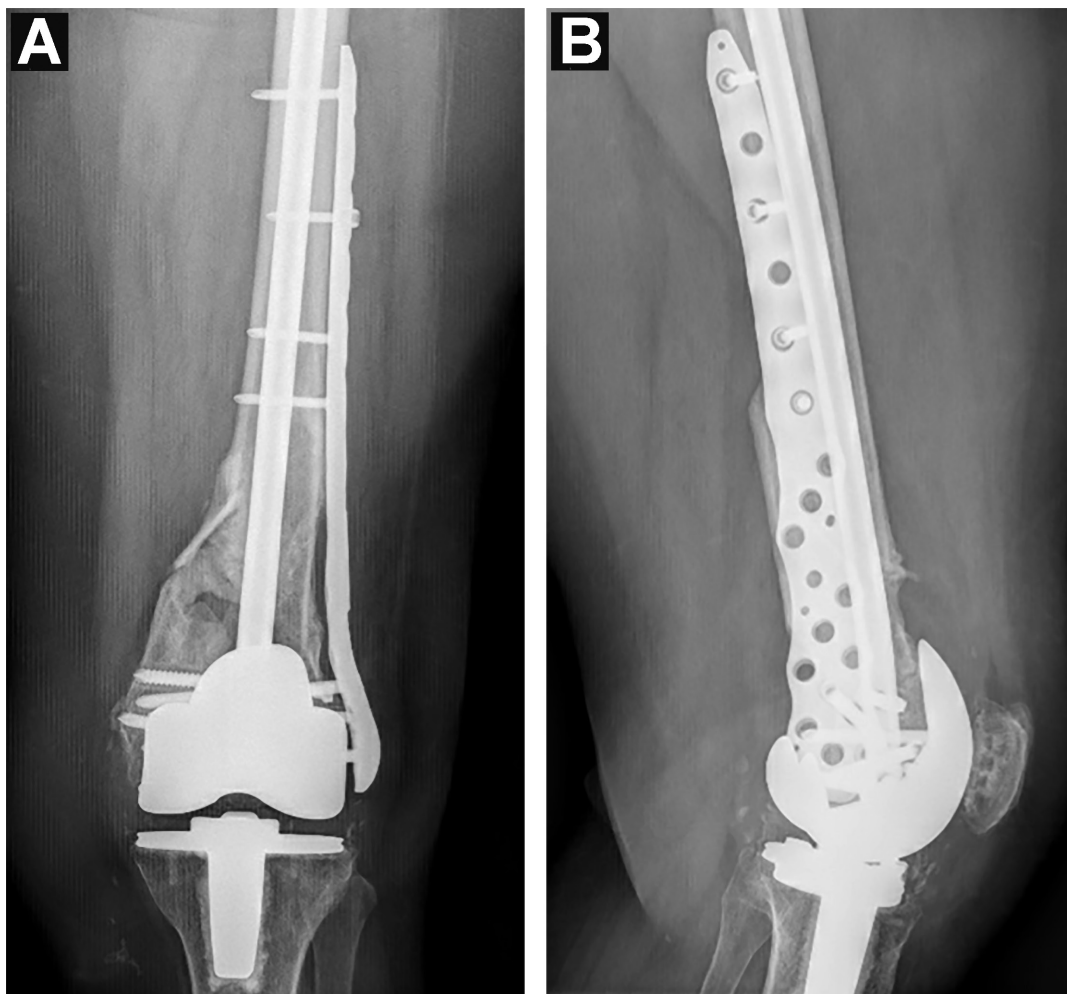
Anteroposterior (A) and lateral (B) X-rays at 6-week post-surgery demonstrating adequate fixation and healing of the periprosthetic femur fracture.
